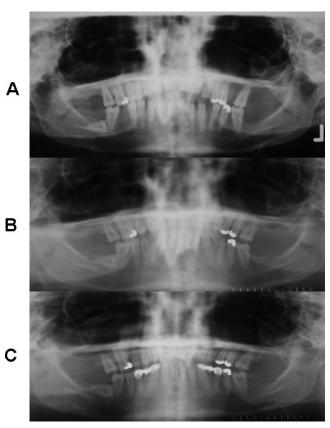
Panoramic radiographs. (A) Pretreatment stage (21 years 4 months). (B) Posttreatment stage (24 years 9 months). (C) Prosthodontic treatment stage (24 years 10 months).
